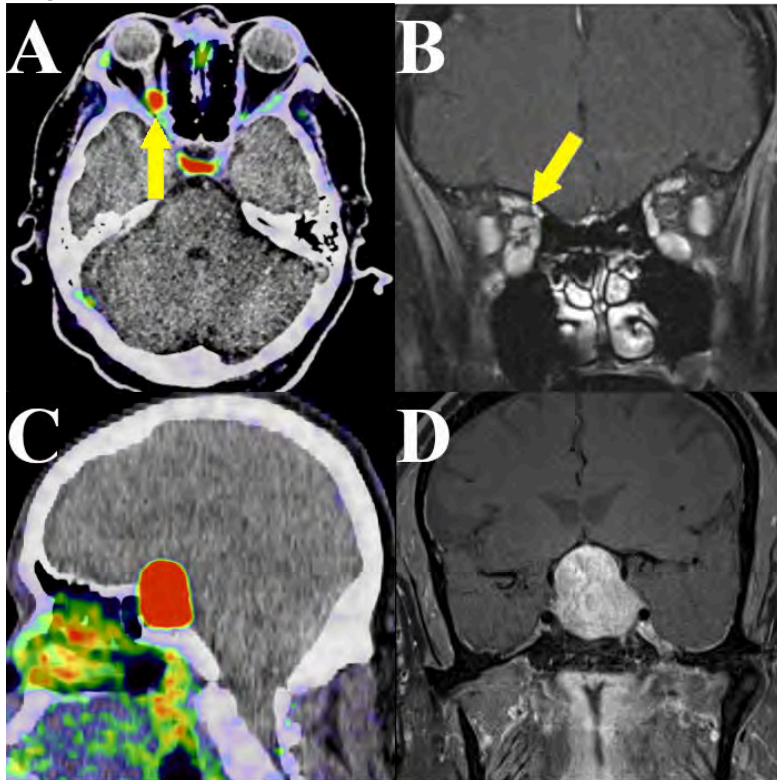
A) SSTR PET uptake is noted at the right optic nerve region (arrow). B) The uptake corresponds to dural based enhancement of the optic nerve sheath on postcontrast T1 MR images, most compatible with an optic nerve sheath meningioma (arrow). C) SSTR PET shows an avid sellar/suprasellar mass. D) Postcontrast MRI confirms a typical appearance of a pituitary macroadenoma.
